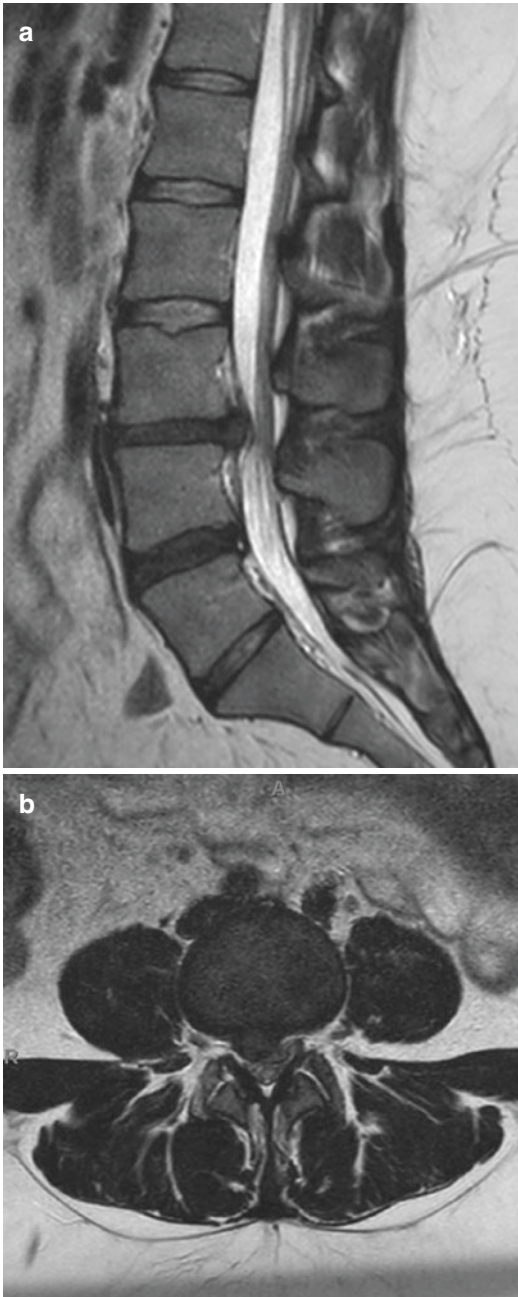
T2-weighted imaging is excellent for evaluation of degenerative disc disease due to contrast in disc material, CSF, and nerve roots. There is a large disc extrusion seen on sagittal (a) and axial (b) T2-weighted sequences in this patient at the L3-L4 level
